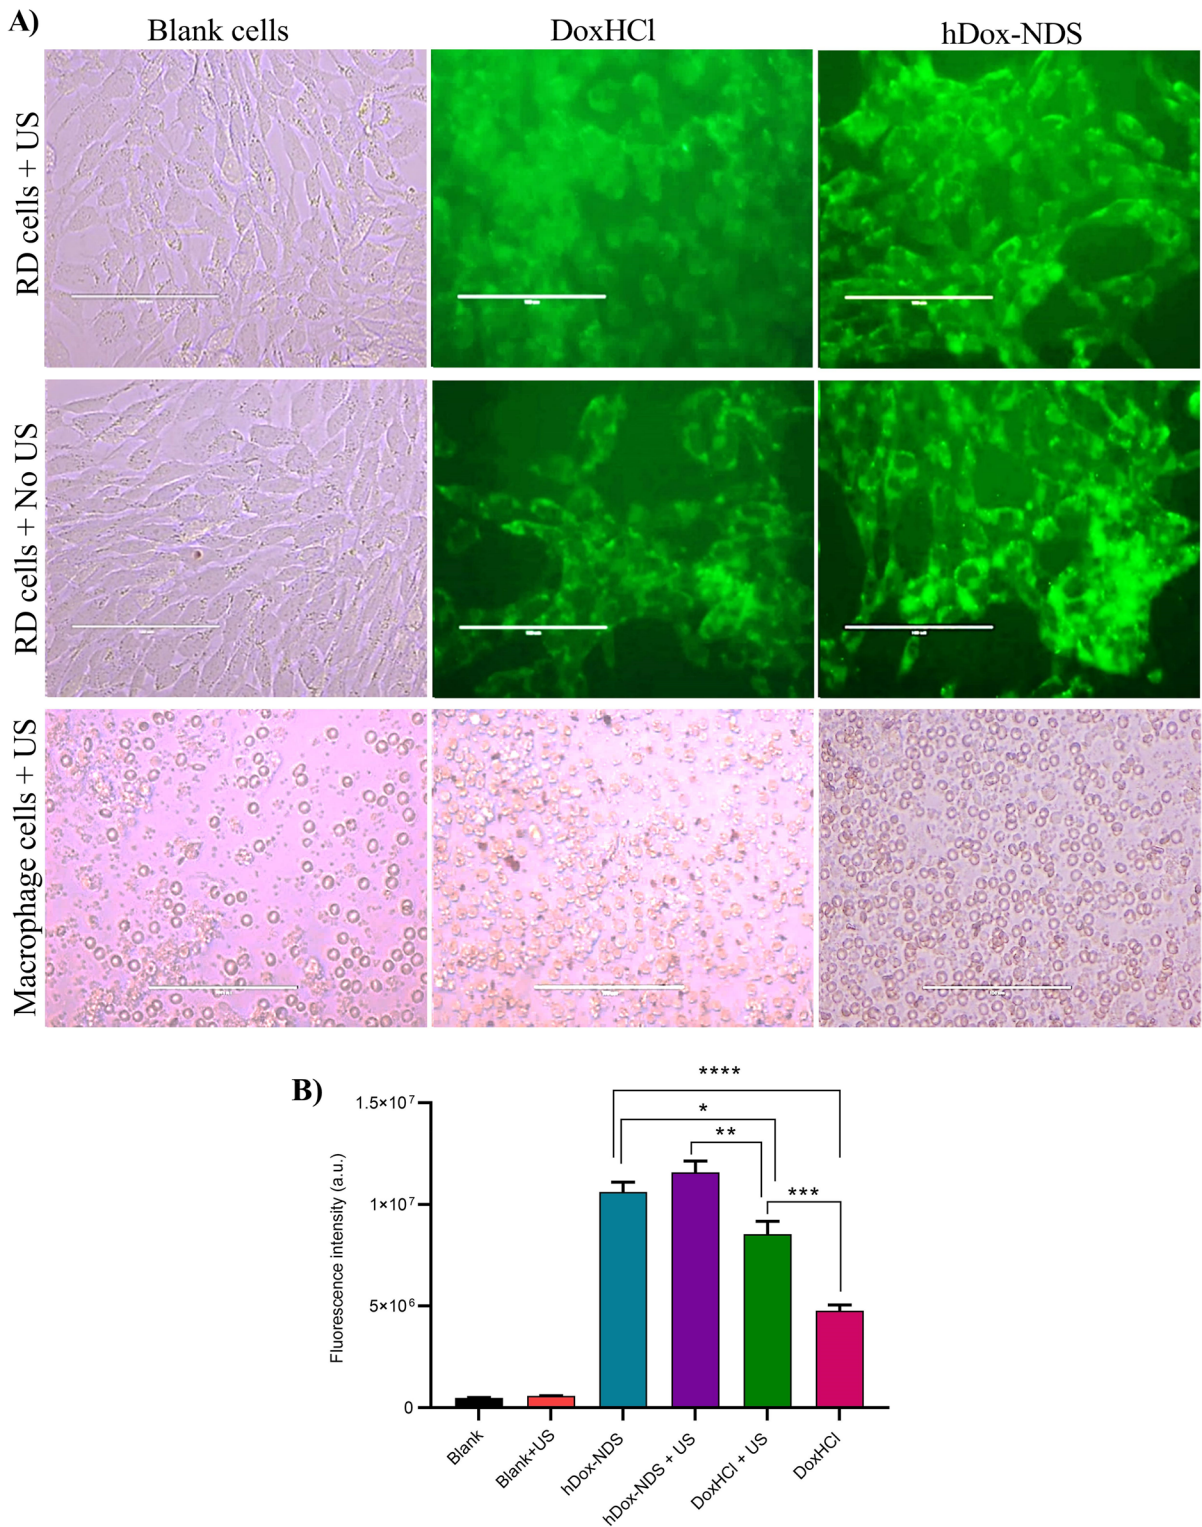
Effects of ultrasound on Dox/hDox-NDS uptake in rhabdomyosarcoma cells and macrophages. A Enhanced uptake is observed after US exposure. Images taken at 20X
